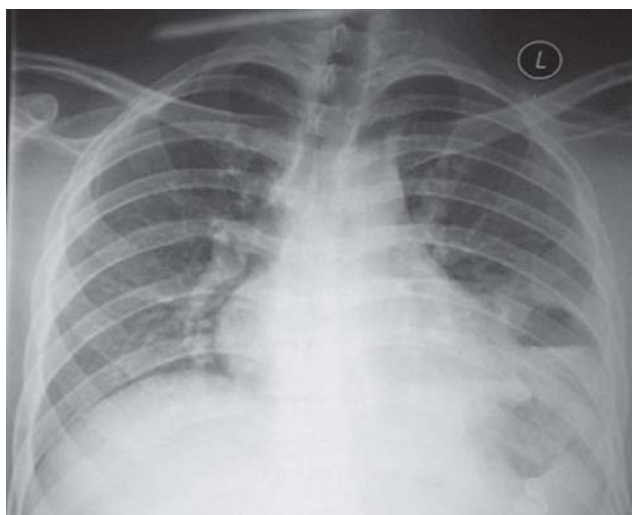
Chest radiograph (postero-anterior view) showing homogeneous opacity in the left mid- and lower-zones with an air-fluid level. Silhouetting of left cardiac border, obliteration of left dome of the diaphragm and left costophrenic angle are also seen.
